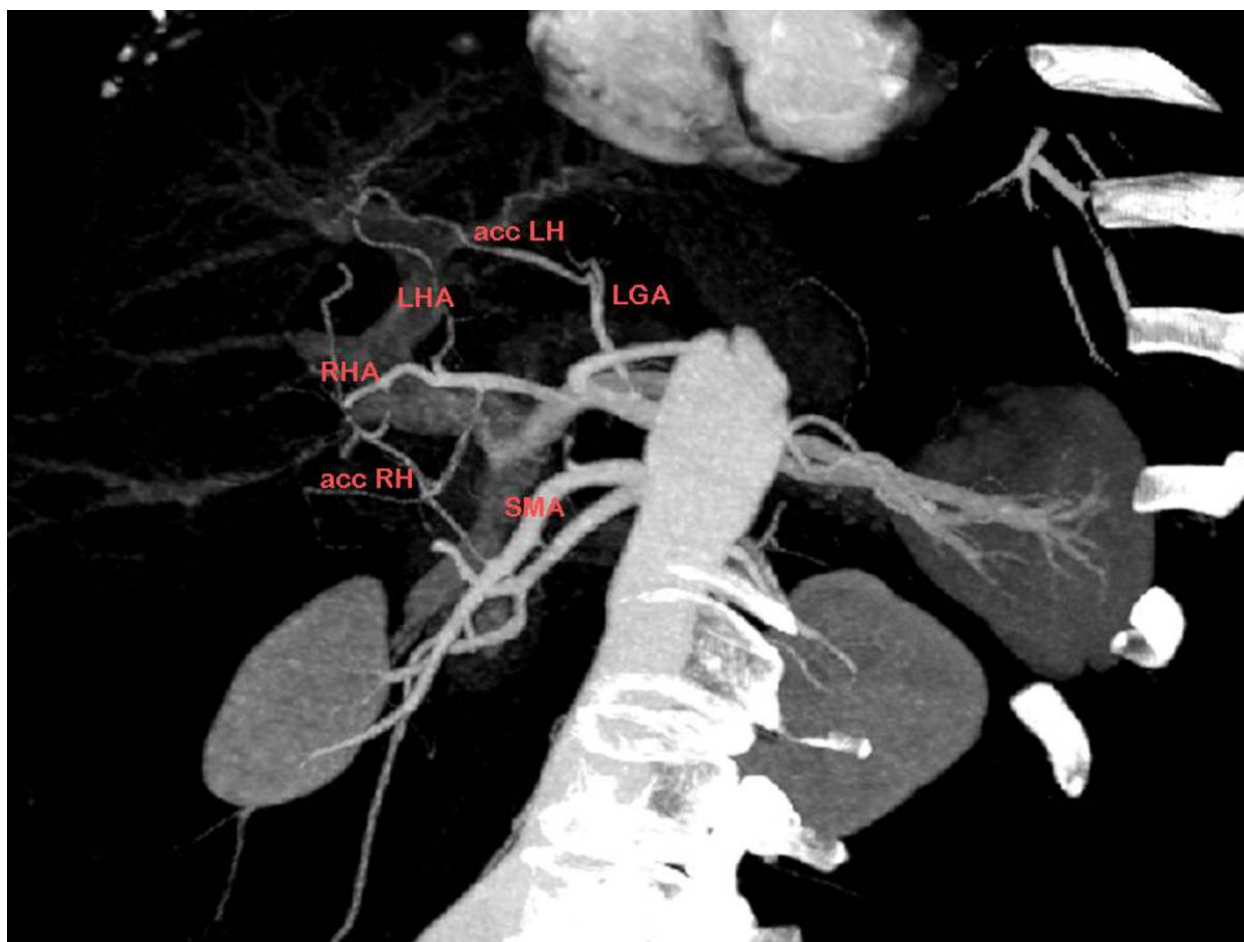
Maximum-intensity-projection CT scan obtained in oblique plane shows accessory right hepatic artery (acc RH) arising from superior mesenteric artery (SMA) and accessory left hepatic artery (acc LH) from left gastric artery (LGA). Common hepatic artery gives off gastroduodenal artery and then bifurcates into left hepatic artery (LHA) and right hepatic artery (RHA).
